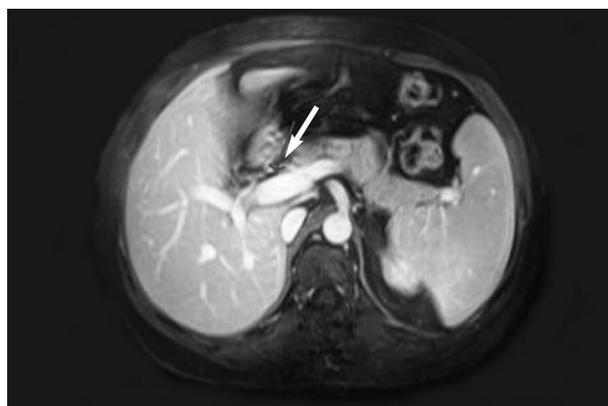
MRI angiography of the portal system; mildly dilated portal vein (arrow).
